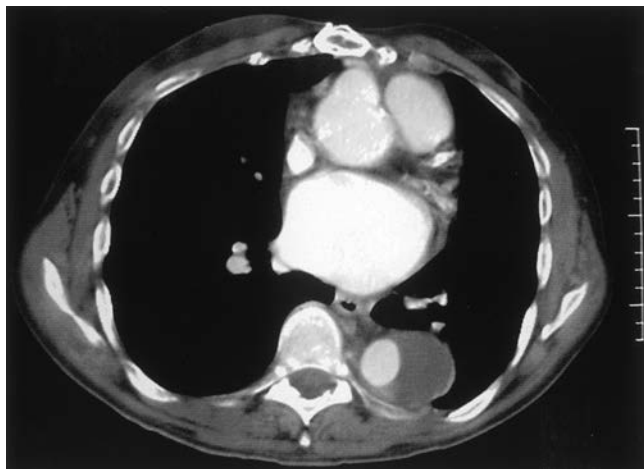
Axial chest CT image of a patient showing large intramural thrombus in the descending thoracic aorta.
